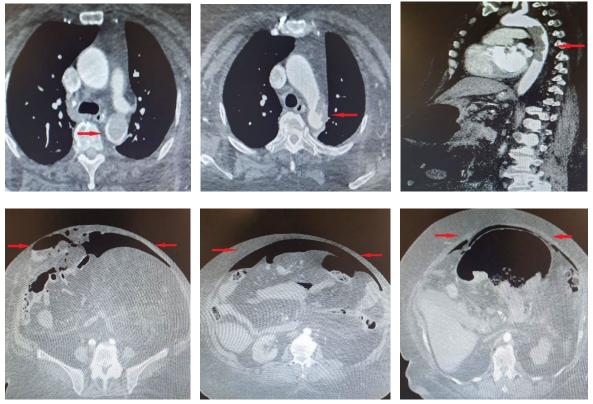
CT Images of the Patient Discussion
